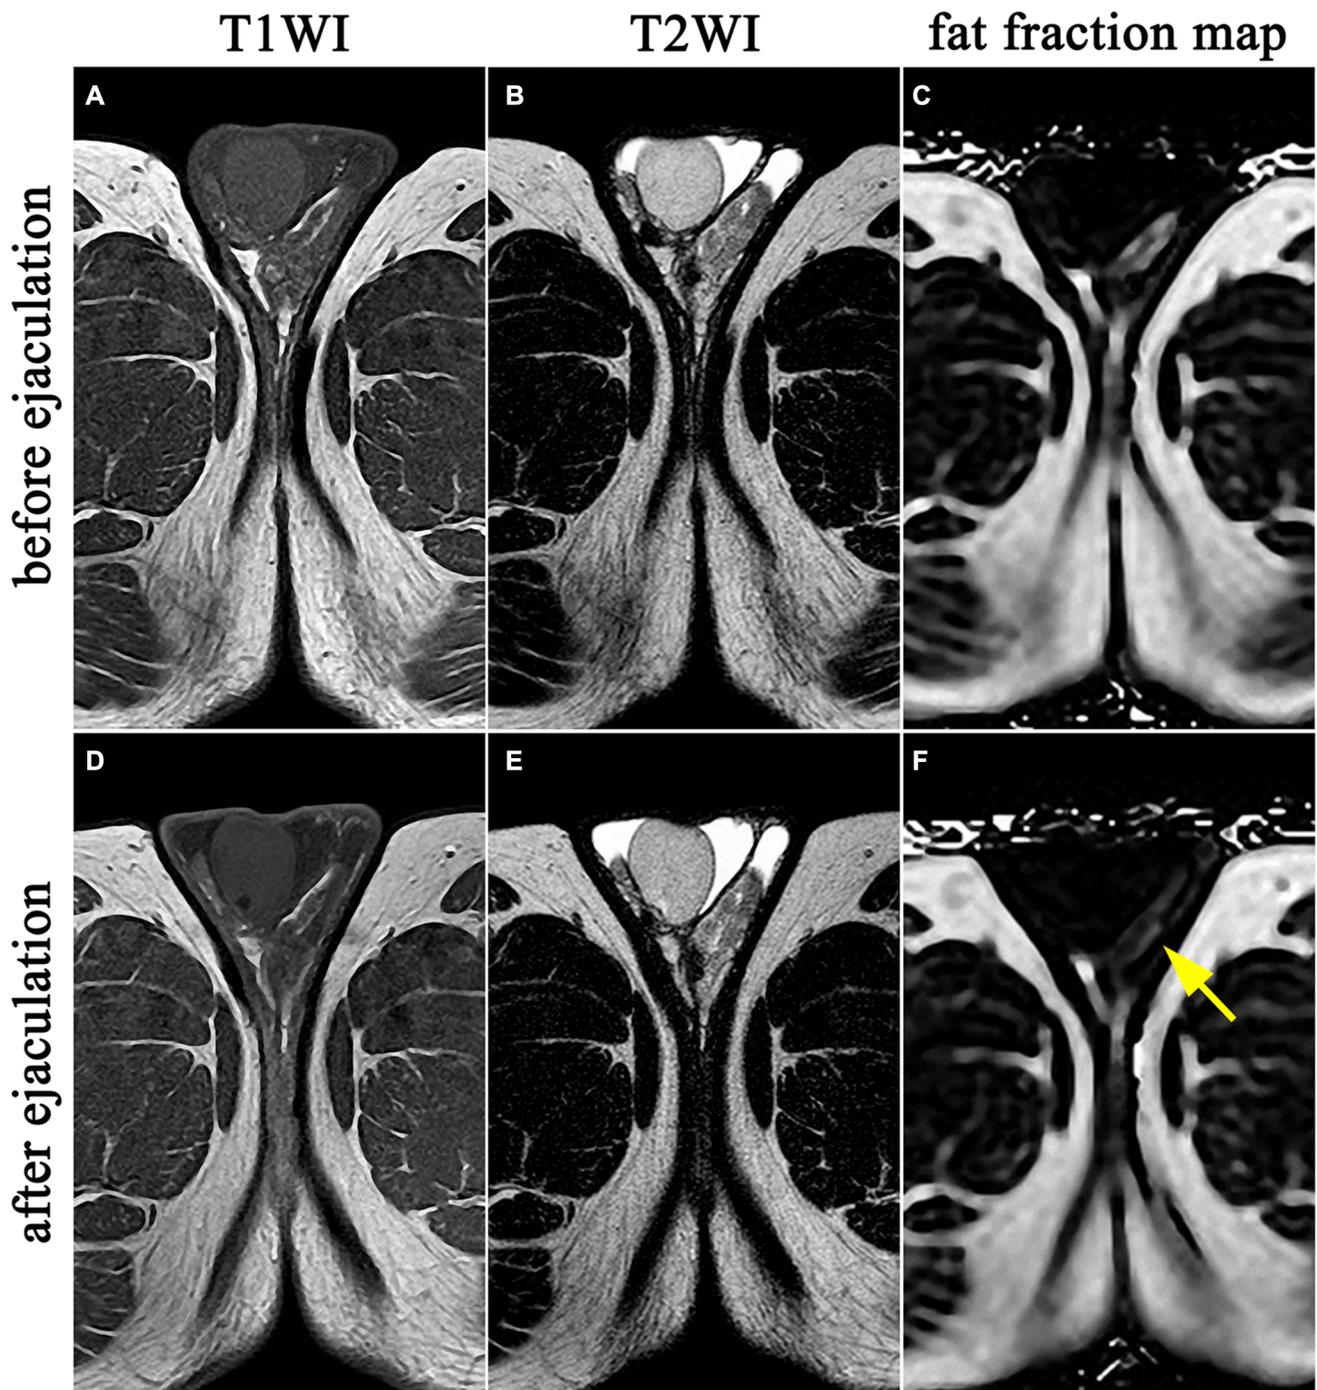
A 32-year-old male with three ejaculations within 12 h. Axial T1-weighted image (a, d), T2-weighted image (b, e), and fat fraction map of the mDIXON Quant sequence (c, f) show that asymmetric fat
